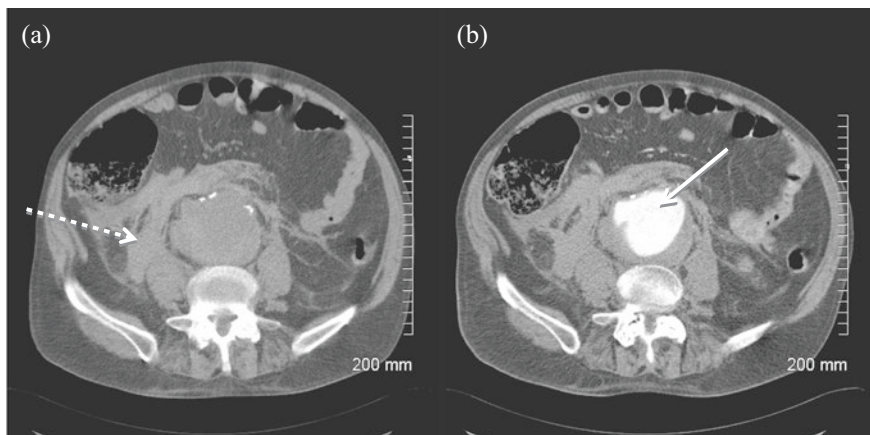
Image a is a noncontrast CT of the abdomen showing large volume fluid in the retroperitoneum, suspicious for hemorrhage, labelled by the broken arrow. Image b is an arterial phase image showing an abdominal aortic aneurysm, as labelled by the white arrow, with free fluid in the retroperitoneum and irregularity of the sac in the 11 o'clock position. Findings were consistent with a ruptured AAA
